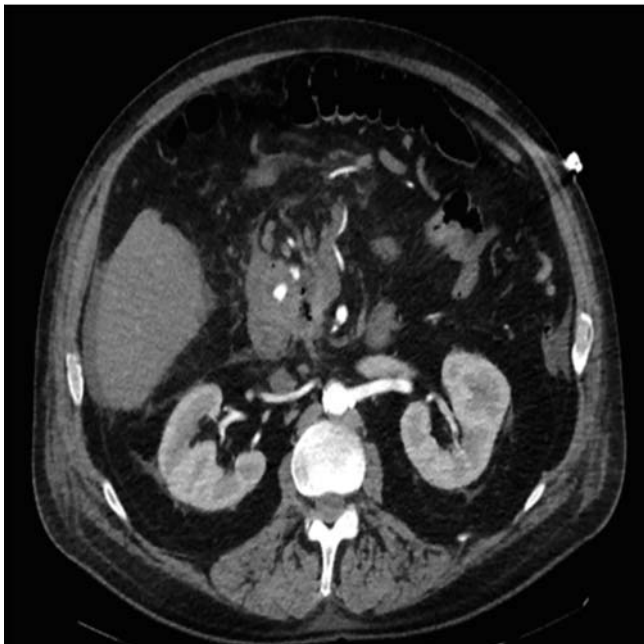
Radiographic evidence of pseudoaneurysm near the duodenal bulb.
